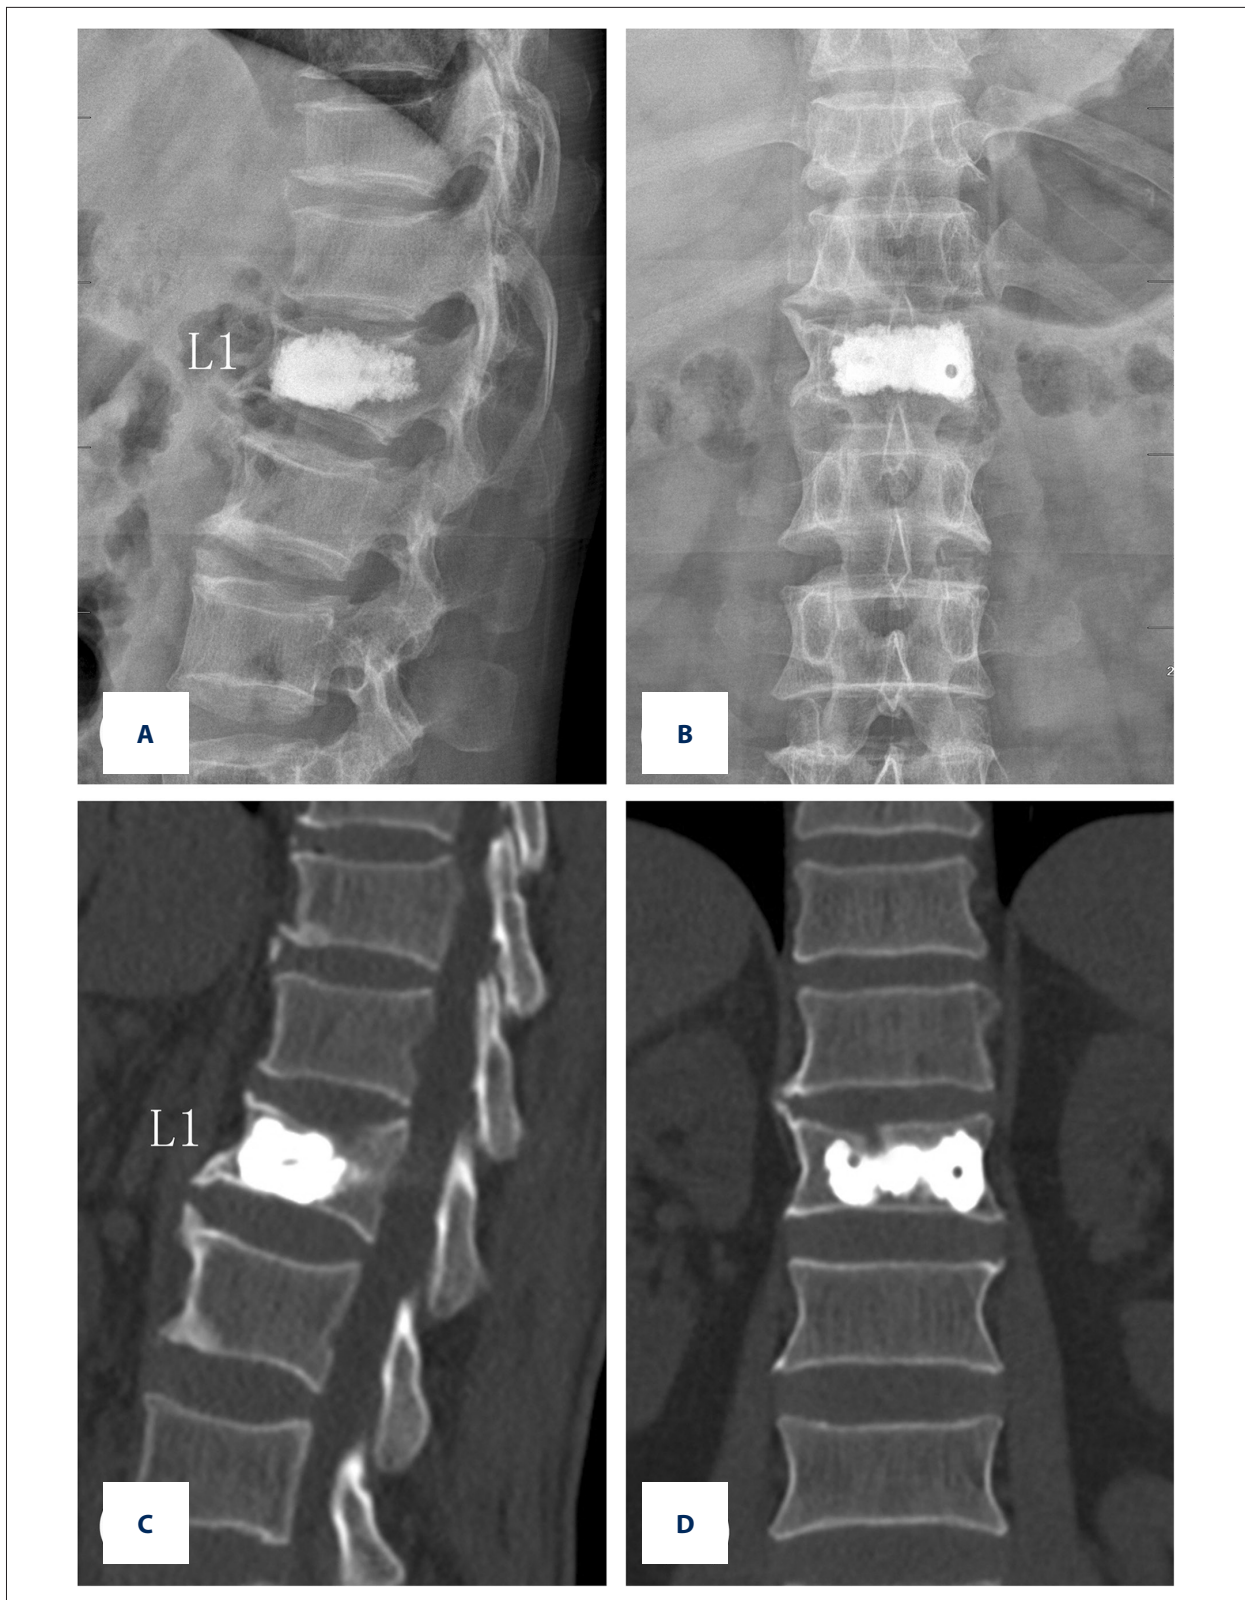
Lateral (A), anteroposterior (B) plain radiograph and sagittal (C), coronal (D) CT images showed cement distribution was diffuse and homogeneous in L1 vertebral body surrounding the Schmorl's node and cement leakage was not noticed.
